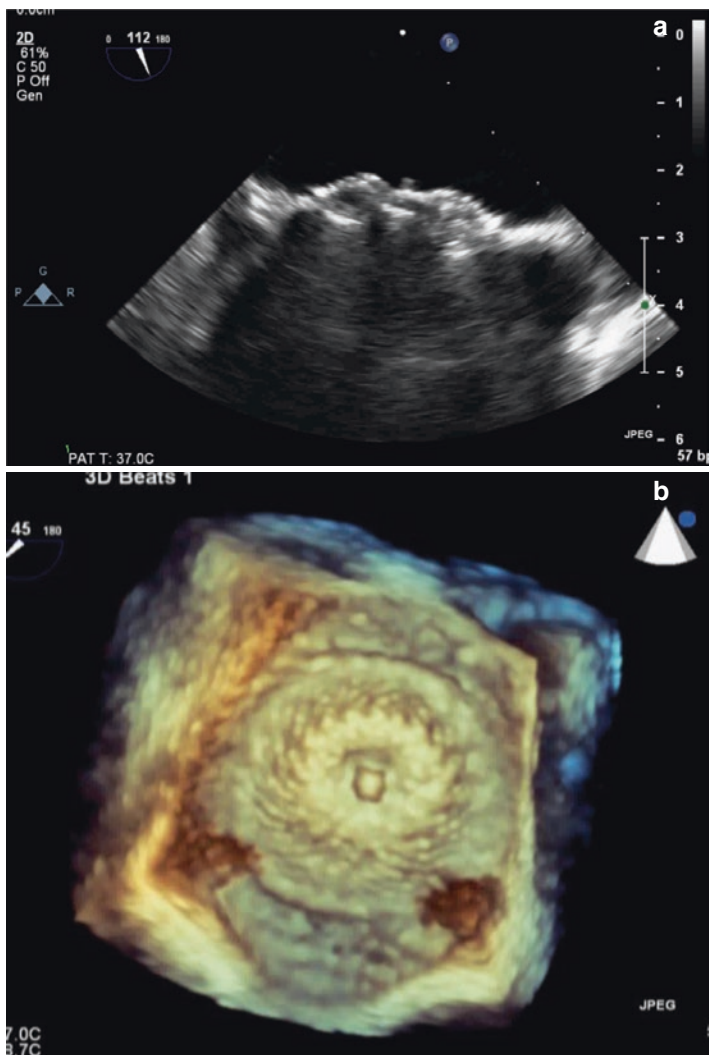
(a) Transesophageal bicaval view of well-seated secundum ASD closure device. (b) 3D TEE imaging of ASD closure device en face
